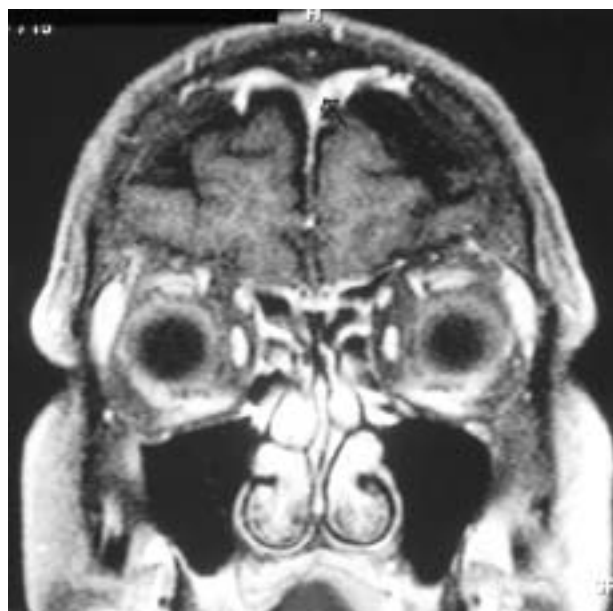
MRI image of leptomeningeal metastasis in non-small cell lung cancer (The arrow shows the lesion)
